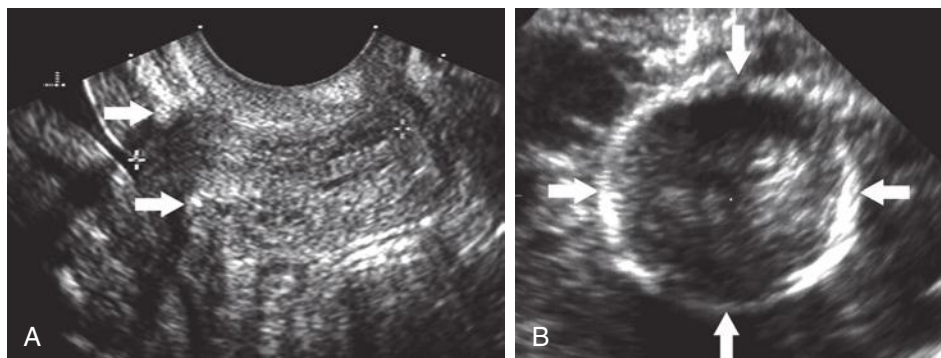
Transvaginal ultrasound images of the cervix with abdominal cerclage. A, Two-dimensional (2D) sagittal ultrasound image of the cervix. In this plane of section, the cerclage suture appears as two bright echoes (arrows) placed near the level of the internal os. The cervical length is measured (calipers). B, Three-dimensional ultrasound-derived image in the axial plane. Note the cerclage suture is depicted in its entirety (arrows).
